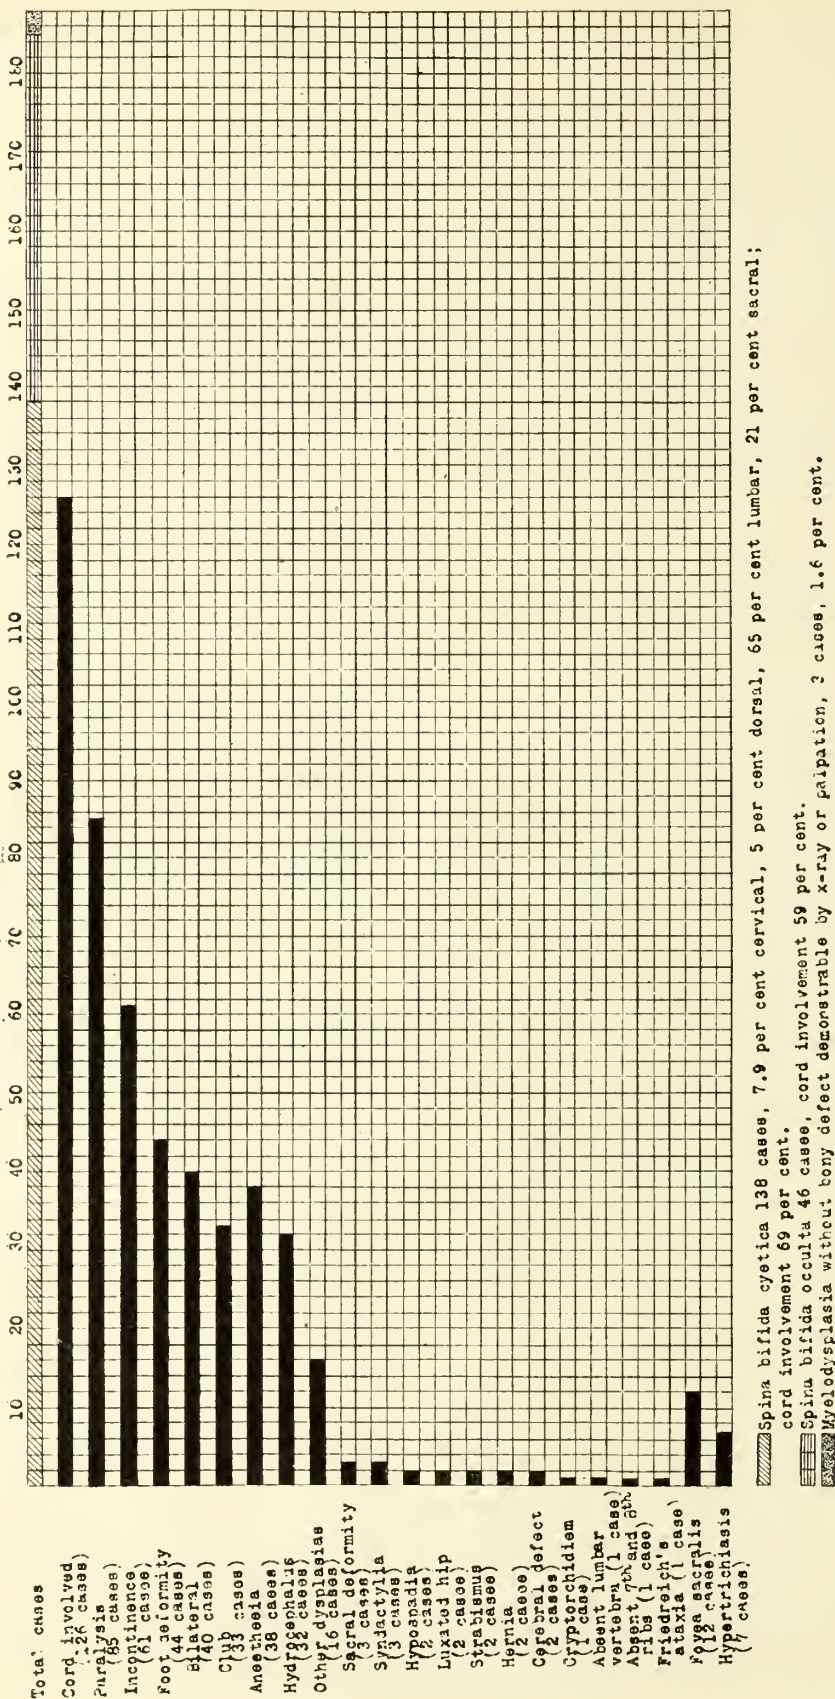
Findings other than x-ray in 187 cases of spina bifida.
